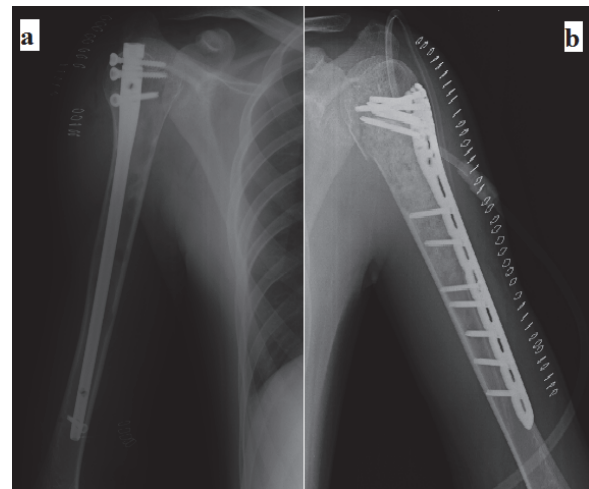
After the operation, the left(3a) and right(3b) humerus X-rays:
